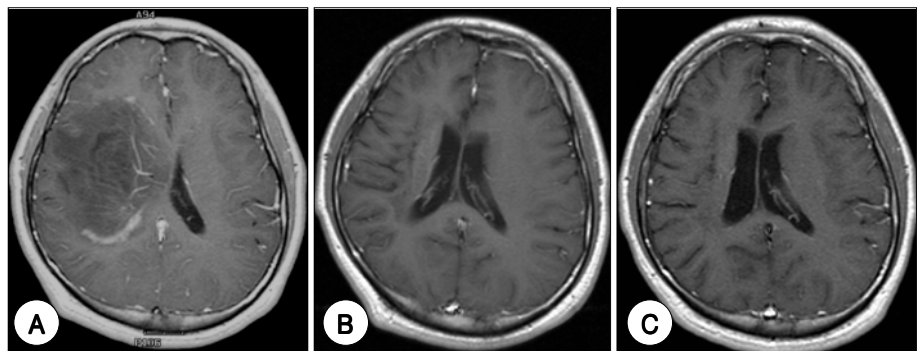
A 22 year-old male with a periventricular and periinsular lesion. A : Initial T1-weighted MR image shows a diffuse, large, and partially enhanced lesion that has mass effect. The pathological result of stereotactic biopsy was gliosis. B : Follow-up T1-weighted MR image (13 months after 1st biopsy) shows a shrunk lesion. C : Follow-up T1-weighted MR image (40 months after 1st biopsy) shows a large area of leukomalacia and no evidence of active disease. At last, this patient was clinically diagnosed as encephalitis.
